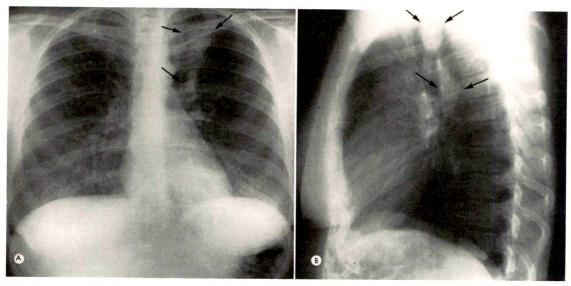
Case II. (A) Posteroanterior and (B) lateral chest roentgenograms of a 31 year old female demonstrating the presence of emphysema in the left upper lobe and a large, smoothly marginated mass within the region of emphysema (upper arrows). The lower arrows point to the less well defined mass representing moderate cylindrical bronchial dilatation immediately adjacent to the point of obstruction of the apical-posterior bronchus.
